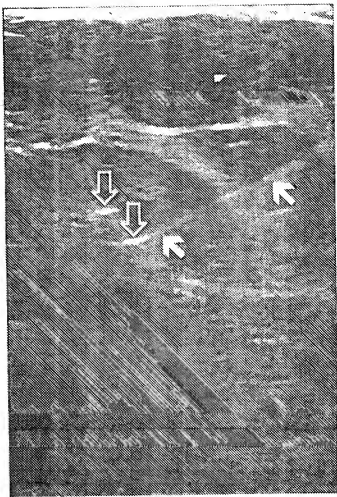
With sonogram guidance, antiradial real-time compound breast sonogram image of left breast at 12 o'clock position shows needle localization wire (solid white arrows) placed into region of Gel Mark Ultra pellets (Seno Rx) (hollow white arrows) within recent stereotactic biopsy cavity.
